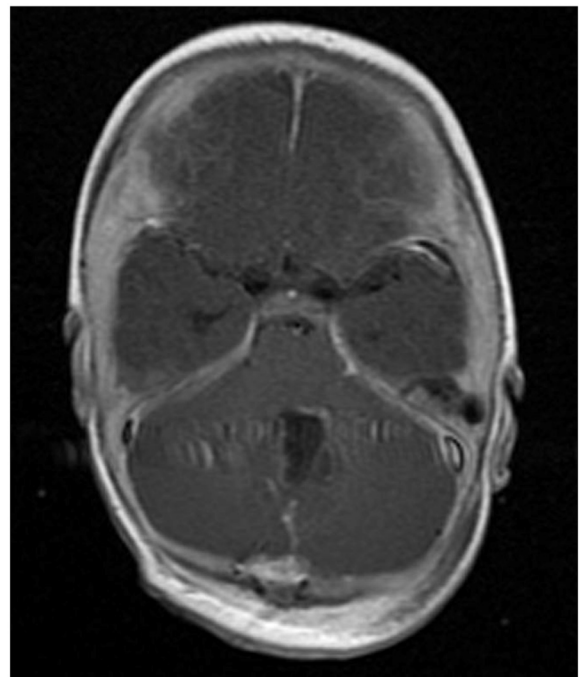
Postoperative axial T1 MRI of the completely resected lesion.
